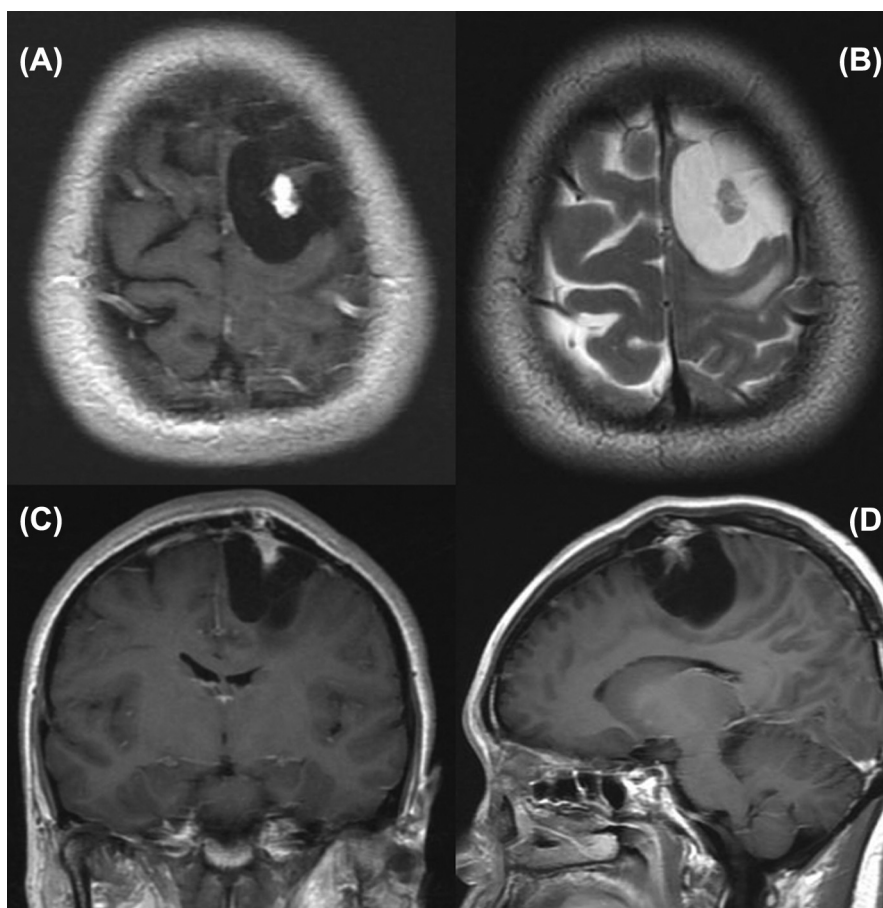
Intra-axial cystic-like lesion over the left frontal area, with a mural nodule. (A) Contrast-enhanced axial T1-weighted image, (B) axial T2-weighted image, (C) coronal T1-weighted image, and (D) sagittal T1-weighted image.
